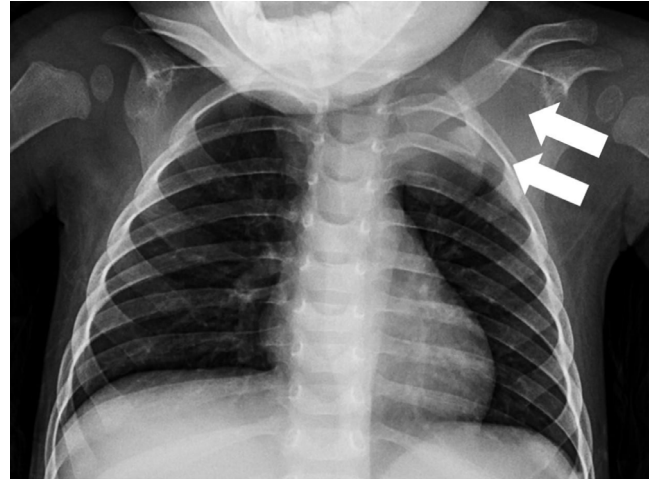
Chest X-ray performed at diagnosis showed focally increased radiopacity superimposed on the left upper lung zone and scapula (arrows).
